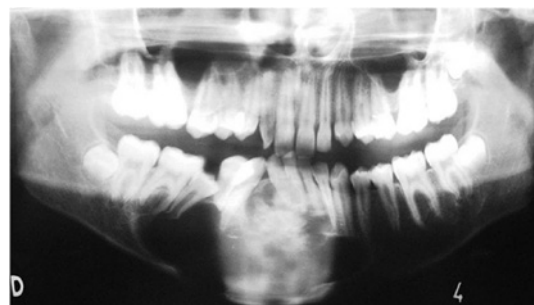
Panoramic radiograph showing large unilocular radiolucent area with calcified material in the anterior region of the mandible
